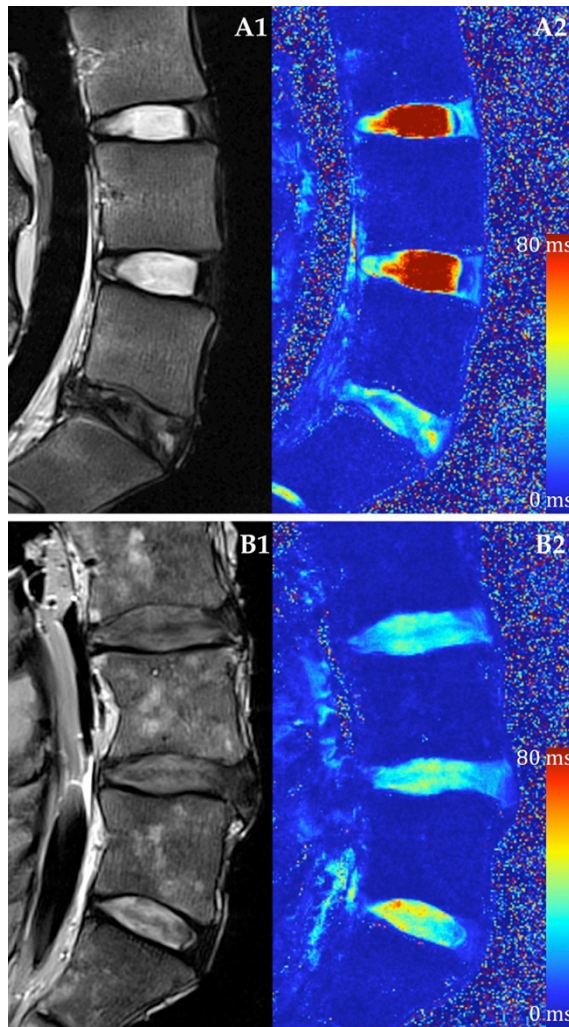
Conventional T2 weighted and T2* Mapping MRI.
